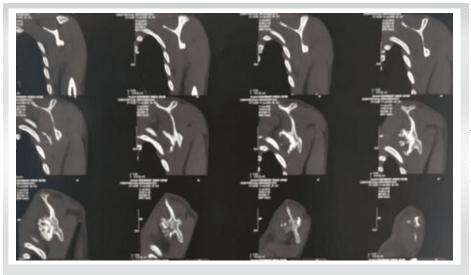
Computed tomography scan — sagittal view.
